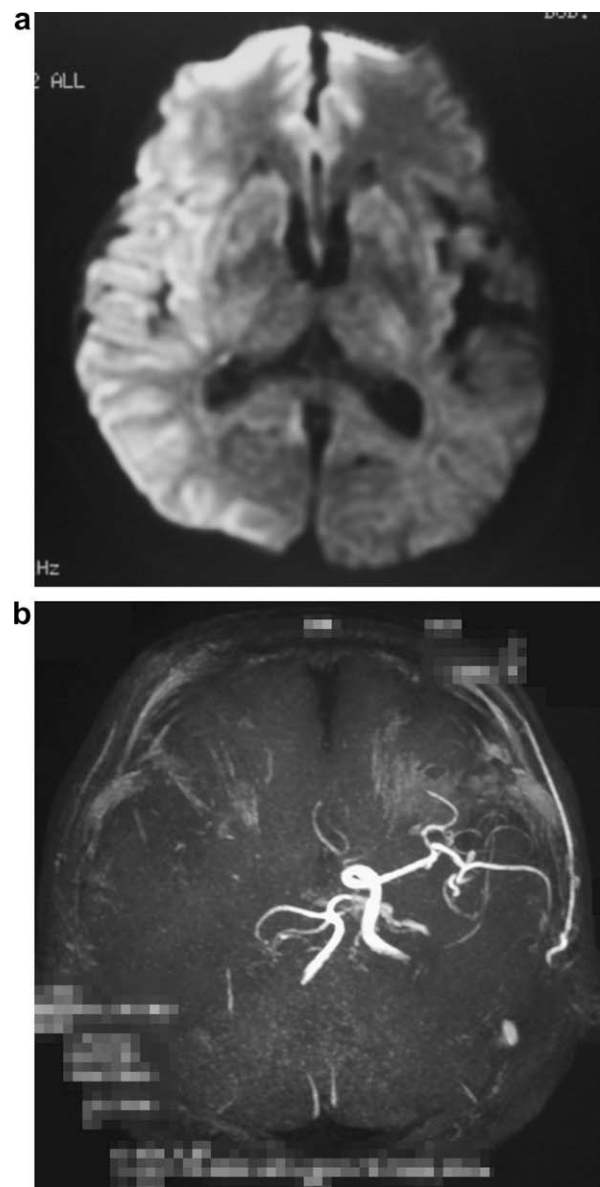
Magnetic resonance (MR) imaging at admission. (a) Cranial MRI by diffusion weighted imaging. (b) Cranial MR angiogram.
